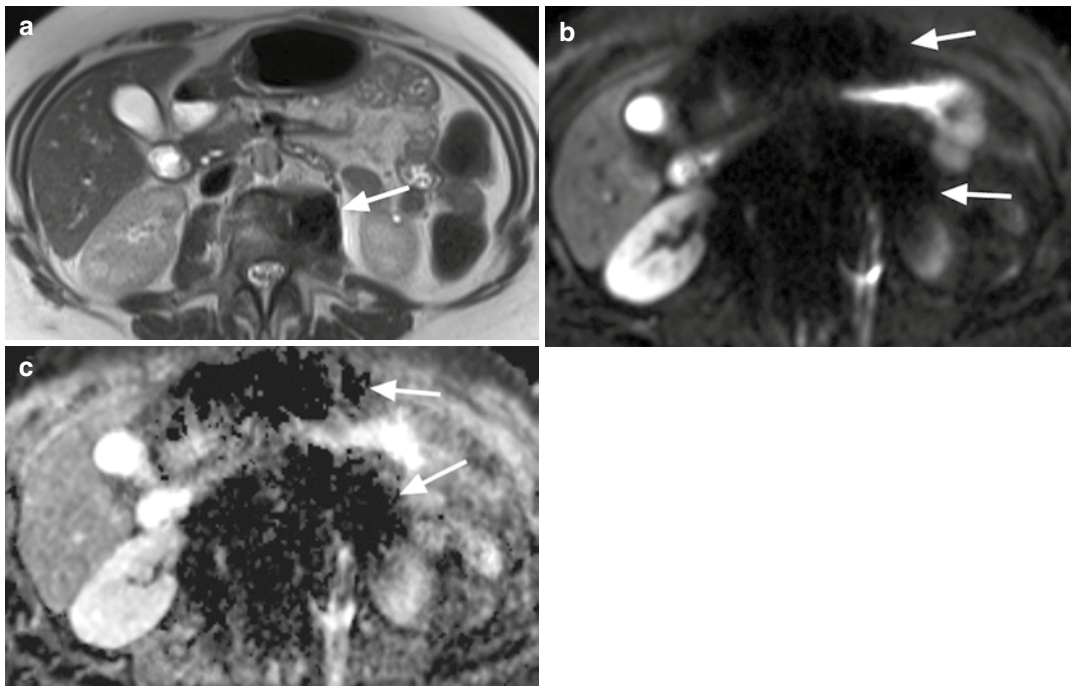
A 45-year-old man with history of spinal surgery. (a) Turbo spin-echo T2-weighted imaging shows susceptibility artefacts arising from surgical screws in the spine (*arrow*). (b) Echo-planar DWI is highly sensitive to magnetic field inhomogeneity, inducing more
